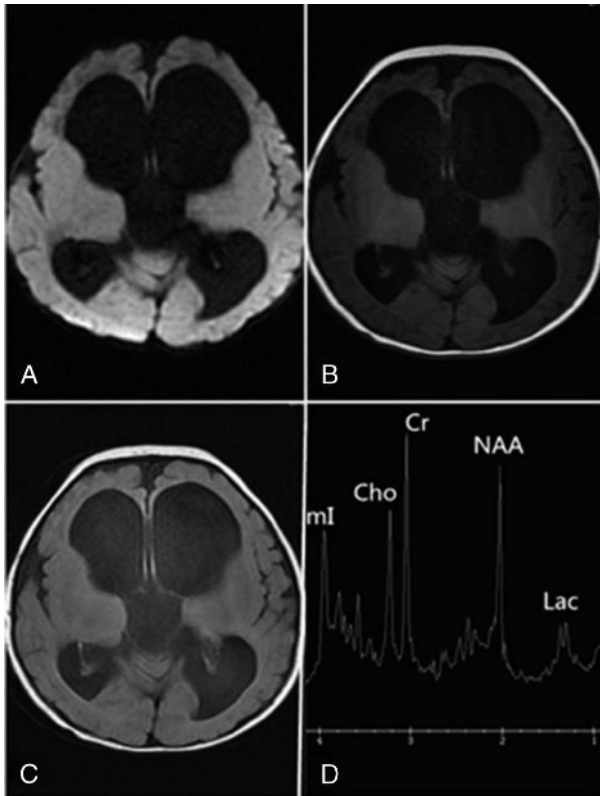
Case 1, M, 4 months. A, Axial DWI. B and C, Axial T1 and T2 fluid-attenuated inversion recovery, all sequence show obvious supratentorial ventricular dilatation and no abnormal signal in the bilateral basal ganglia. D, ^1H -MRS from the basal ganglia show Lac peak at 1.3 ppm.
